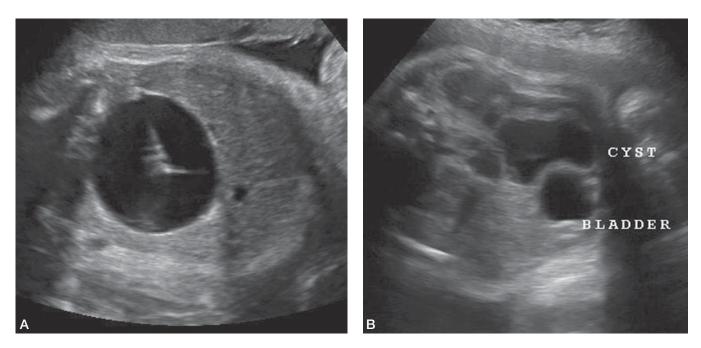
A. Prenatal image documenting ultrasound-guided drainage of a fetal ovarian cyst; B. axial image showing the same fetal ovarian cyst after aspiration.
